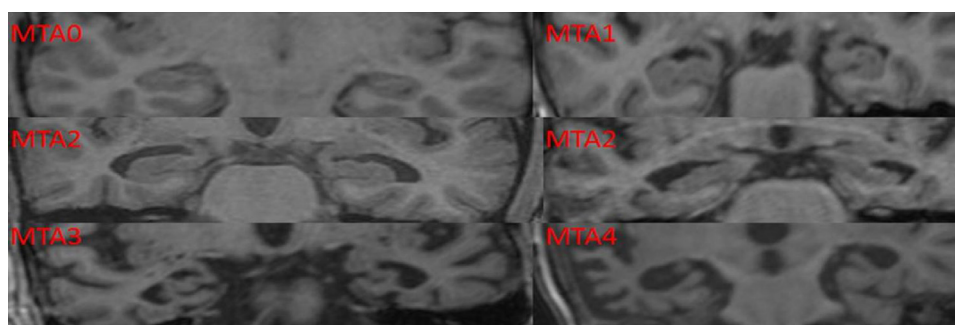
Sheletens Medial Tempal Lobe Atrophy (MTA) Rating Scale. Scoring was done as follows (0) (0) scores on left and right sided were given if there was no visible atrophy on T1 weighted coronal MRI images. The scores of (1) (1) left sided were given to those with minimal atrophy. Those with moderate atrophy were rated as (2) (2) left and right sided respectively. Those with moderate atrophy were given the score of (3) (3) and scores of (4) (4) were given to those with marked atrophy.
